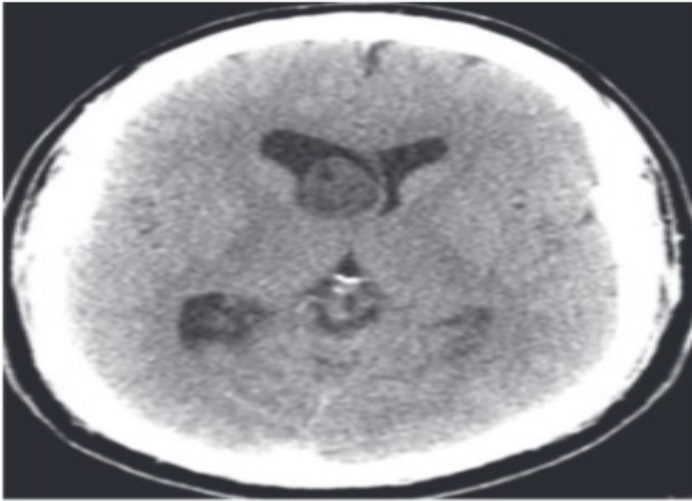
Central neurocytoma in a 27-year-old woman with a 4-month history of headaches. (a) Axial nonenhanced CT image shows a lesion located centrally within the lateral ventricles. Small foci of hyperattenuation consistent with calcification are present, as well as foci of hypoattenuation consistent with cystic areas. Hydrocephalus is present. (b) Axial T2-weighted image shows a large mass that is slightly hyperintense to gray matter located centrally around the septum pellucidum. Foci of hyperintensity consistent with cystic regions are noted. No increased signal intensity is appreciated in the adjacent brain parenchyma. (c) Axial contrast-enhanced T1-weighted image shows moderate heterogeneous enhancement.
